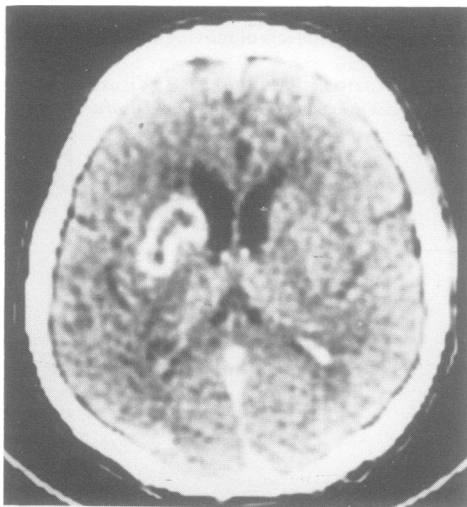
Fig Post-contrast CT scan 8 days from onset. The luxury perfusion well defines the infarcted area.
